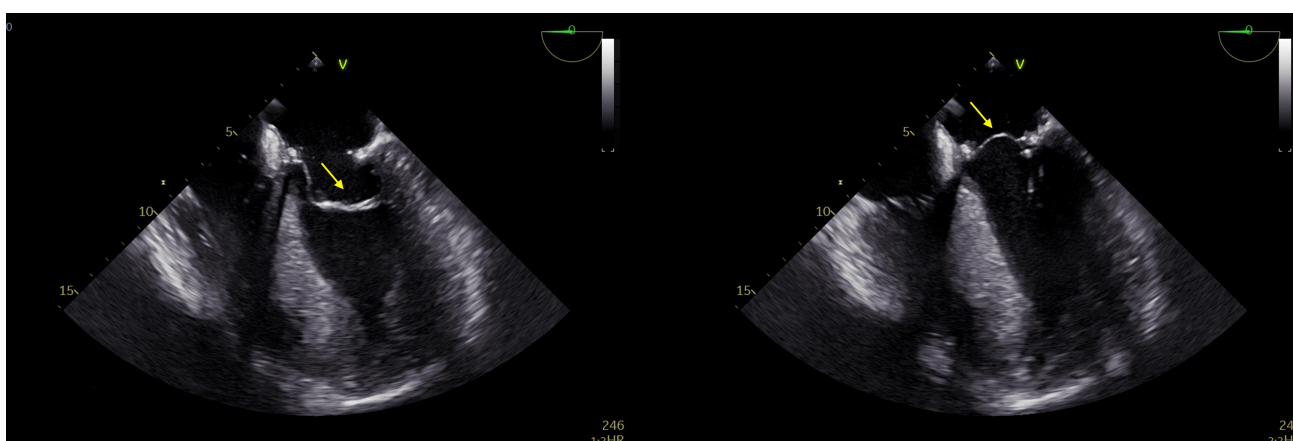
Transesophageal Echocardiography Status Post Septal Myectomy and Anterior Mitral Leaflet Extension. Mid-esophageal four-chamber echocardiographic view showing the anterior mitral leaflet extension patch (yellow arrow) in diastole (left panel) and systole (right panel). A mitral valve ring annuloplasty has also been implanted.
